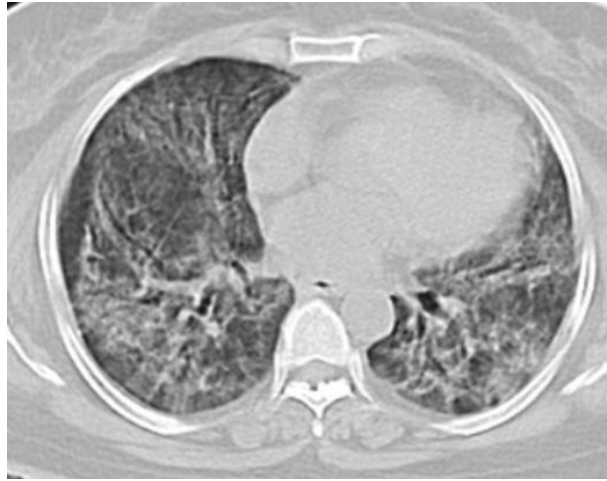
HRCT thorax of the same diabetic patient patchy areas of ground glass opacities with adjacent fibrosis in bilateral lung fields.
